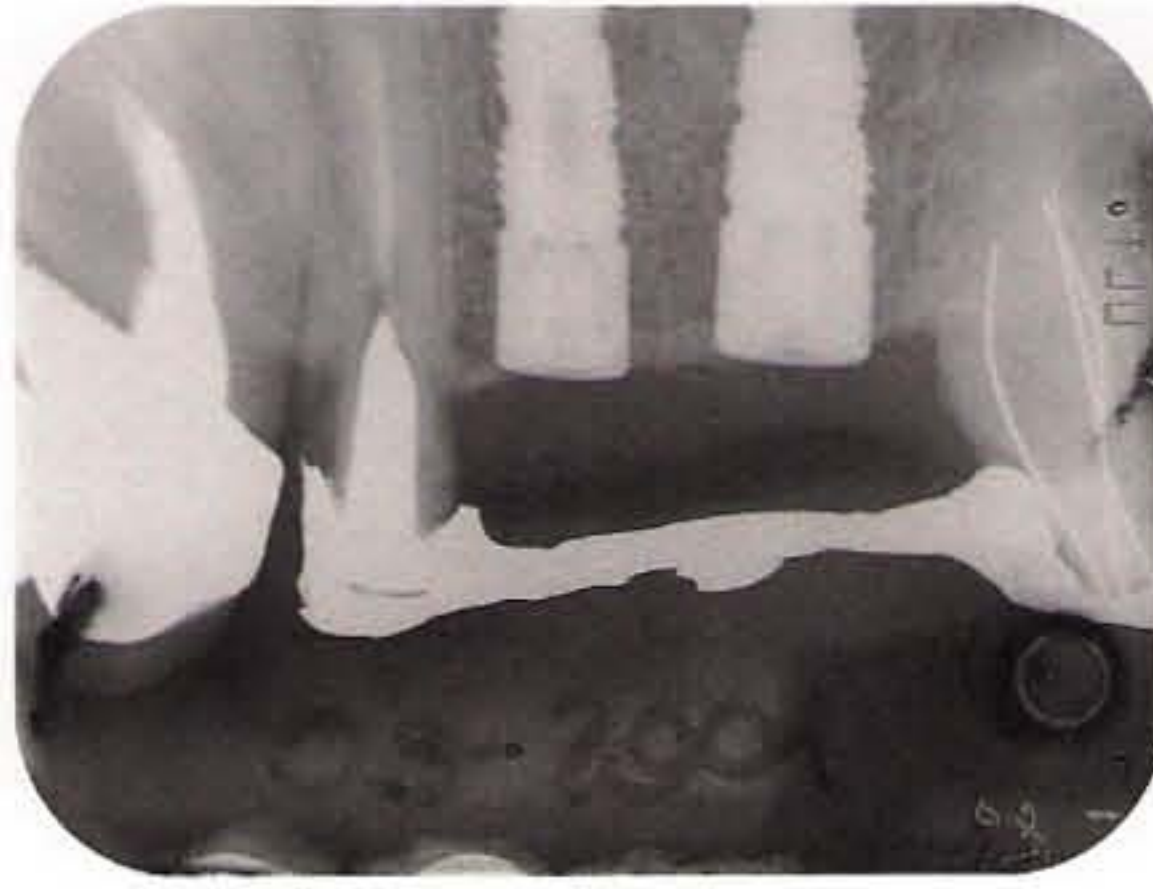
Postsurgical radiograph taken after the installation of two conical implants using the edentulous ridge expansion technique.
